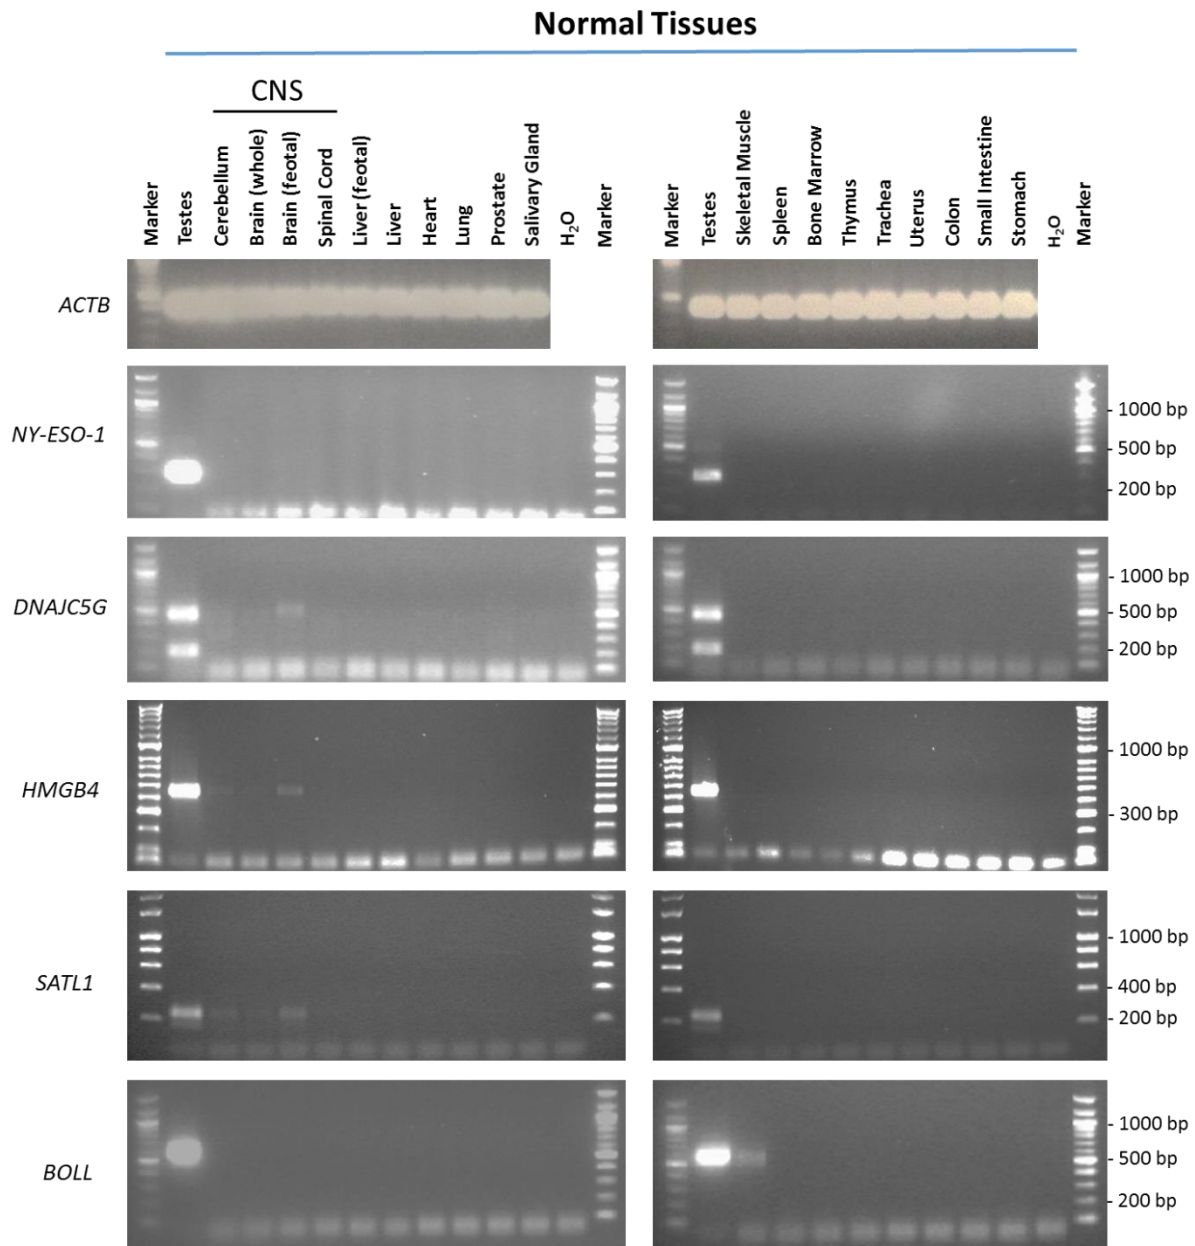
RT-PCR analysis of putative CT genes that indicated limited expression in somatic tissues other than testis.
